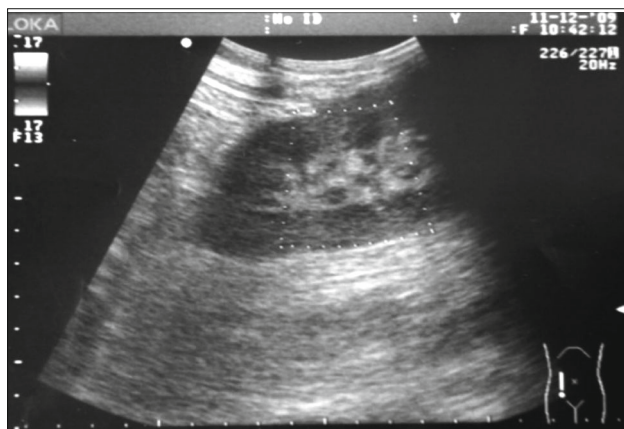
Renal artery thrombosis of transplanted kidney diagnosed by Colour Doppler ultrasonography.
